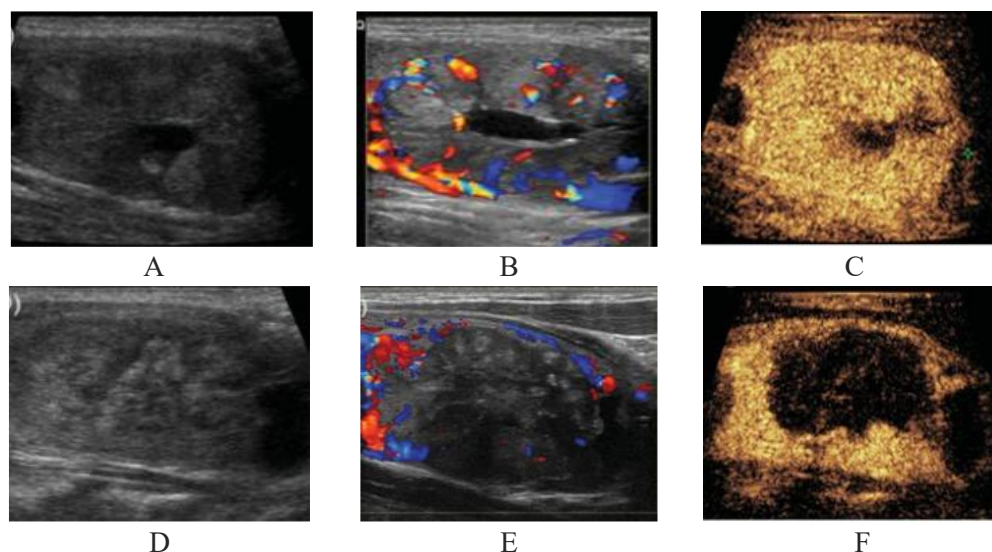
Results of ultrasound, color Doppler and contrast-enhanced ultrasound.
